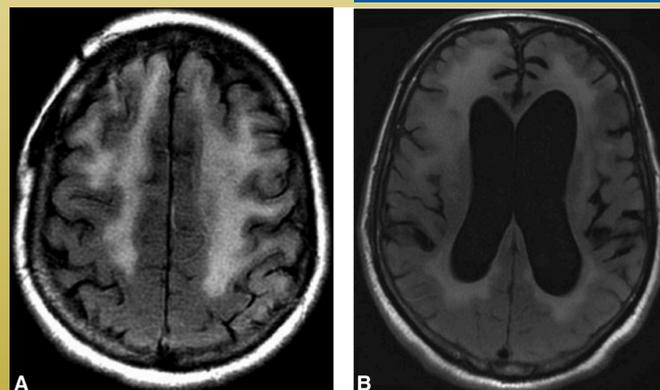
sample Axial T2 FLAIR images - levels of the centrum semiovale (A) and lateral ventricles (B) seen in pt with encephalitis/inflammation 2/2 ICI use
